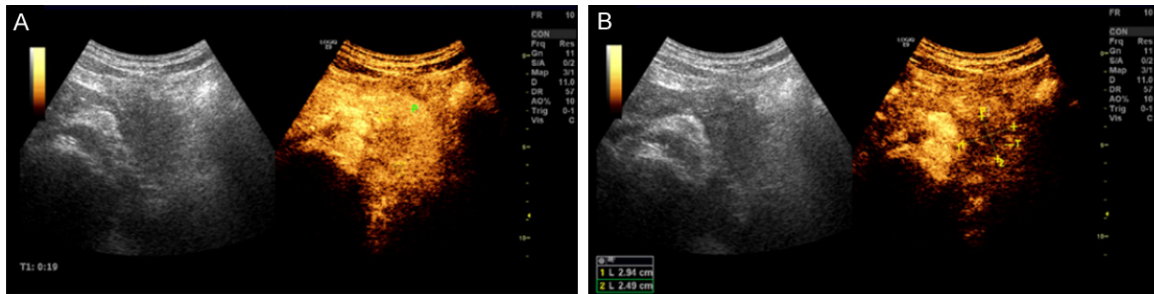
Contrast-enhanced ultrasound (CE-US) found a heterogeneous, hypoechoic, and slightly enhancing lesion at the pancreatic body region (A); lesion measured 2.9×2.5 cm (B).
